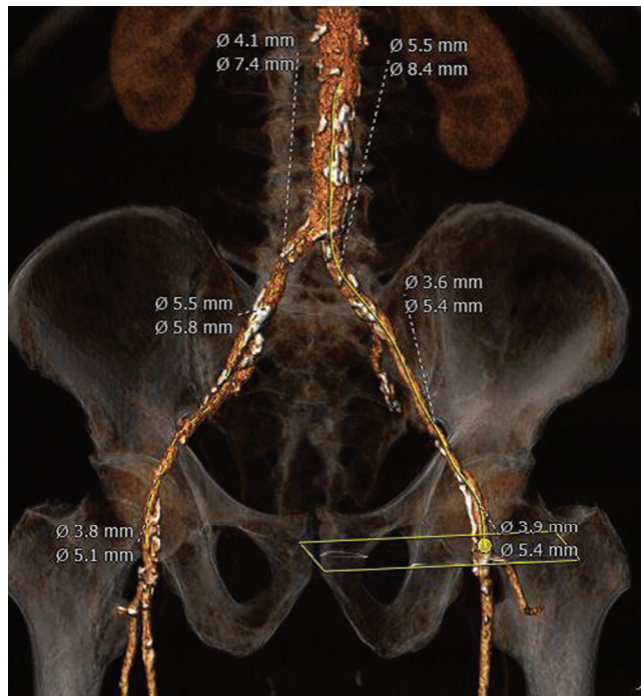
■ Contrast computed tomography with three-dimensional reconstruction showing severe iliac-femoral calcifications.
